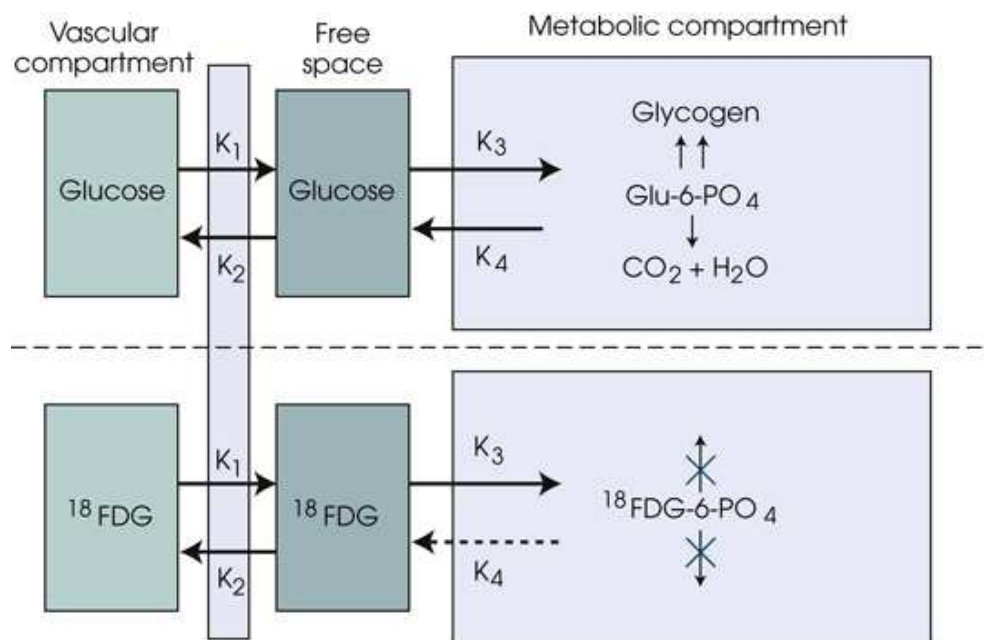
Glucose compartmental model (*above dashed line*) compared with the ^{18}F -FDG model (*below dashed line*). ^{18}F -FDG does not go to complete storage (glycogen) or metabolism ($\text{CO}_2 + \text{H}_2\text{O}$) as does glucose. The constants (K) refer to reaction rates for moving substances from one compartment to another. *Dashed arrow* refers to extremely small K value that can usually be neglected.
